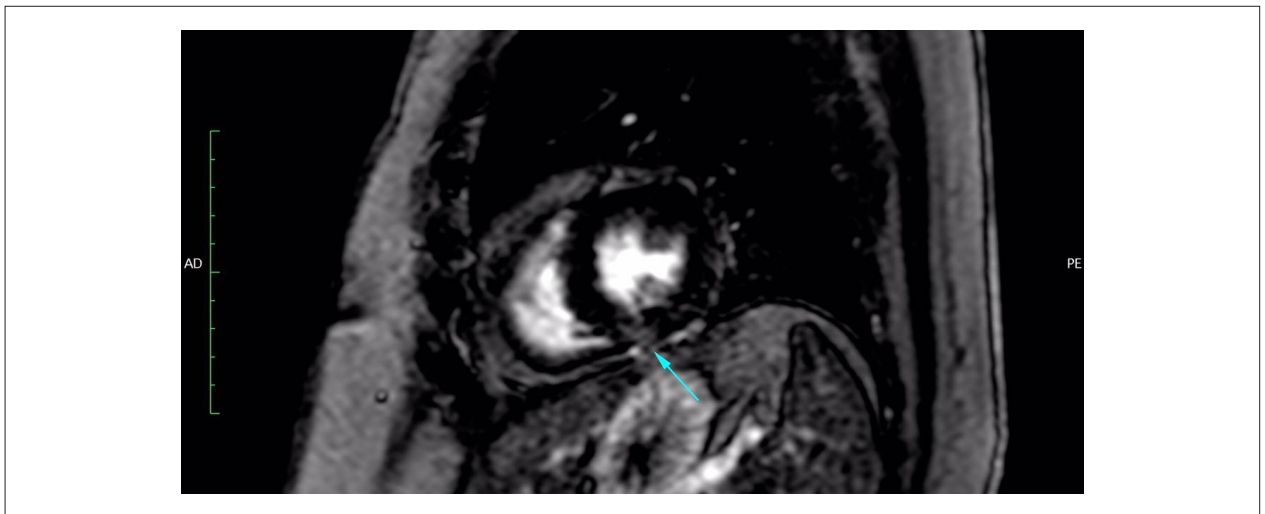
Short-axis: left ventricular late gadolinium enhancement on cardiac magnetic resonance imaging. Note epicardial delayed enhancement (arrow).
